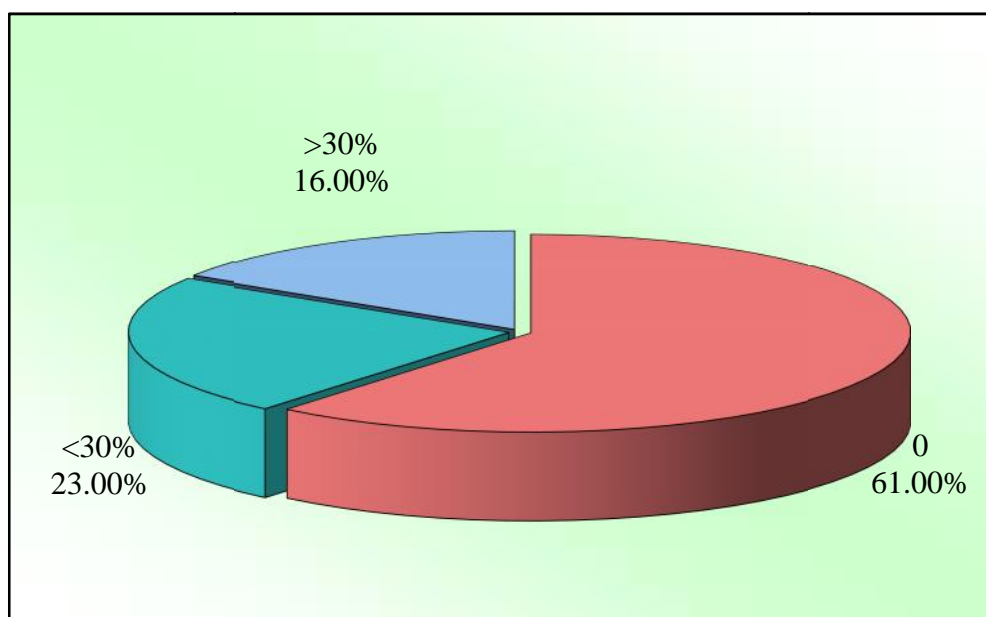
CT abdomen appearance wise distribution of acute pancreatitis patients
